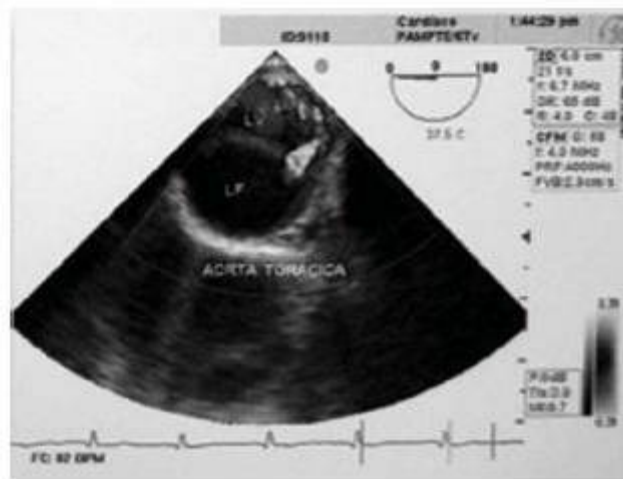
Echocardiogram: aortic dissection (double lumen)
